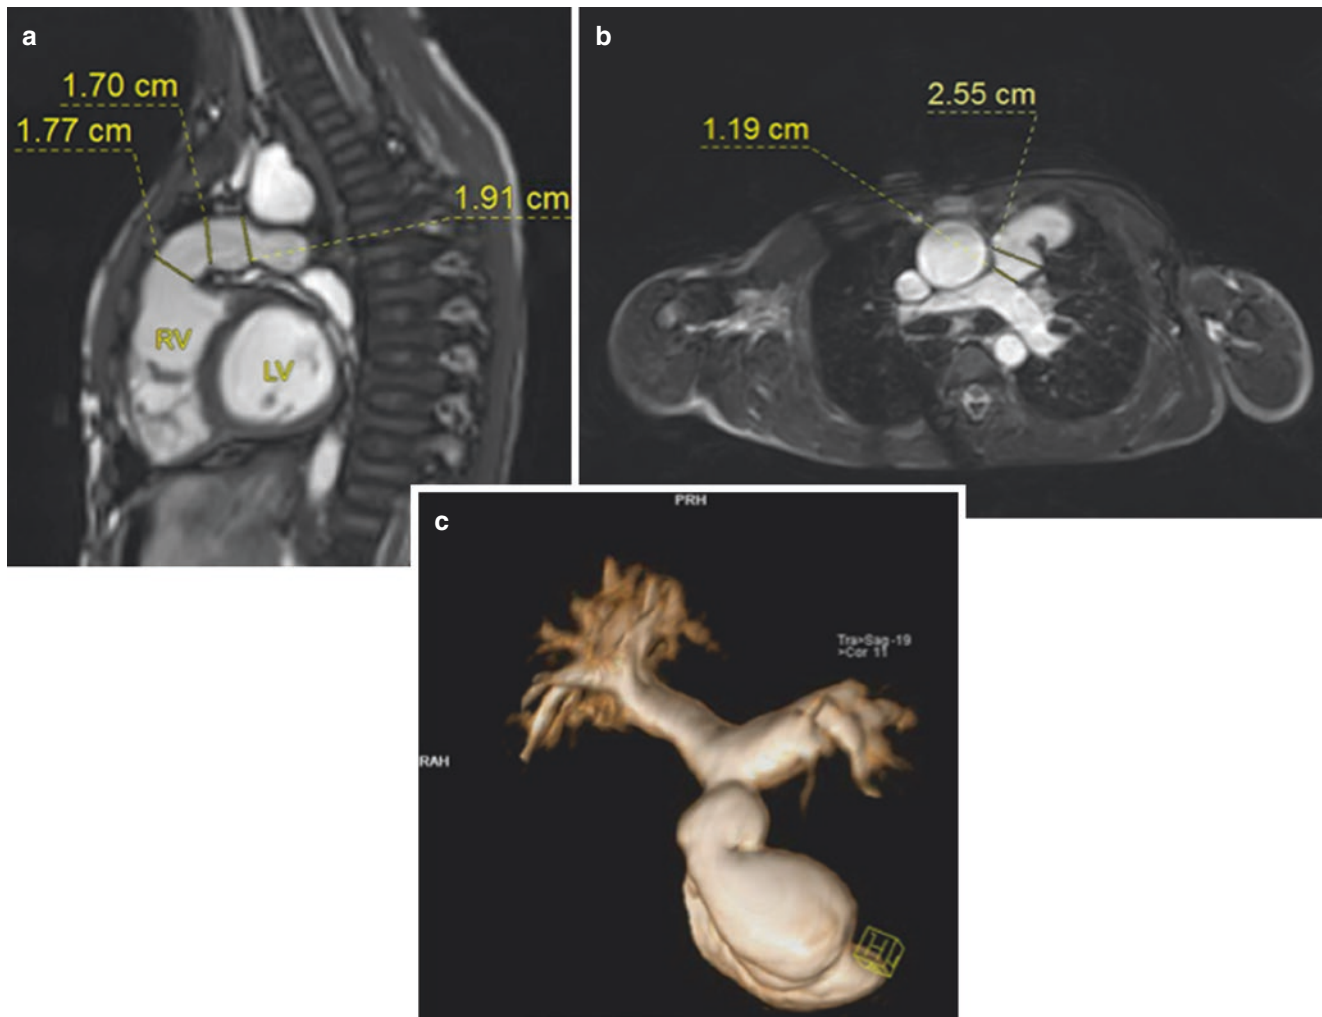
Cardiac MR images (SSFP) in a patient with dysfunctional homograft between the right ventricle and pulmonary artery. The regurgitant fraction in this patient was 51%. (a) Cine SSFP sagittal-oblique image through the right ventricular outflow tract demonstrating various measurements obtained. (b) Axial oblique 3D SSFP demonstrating
